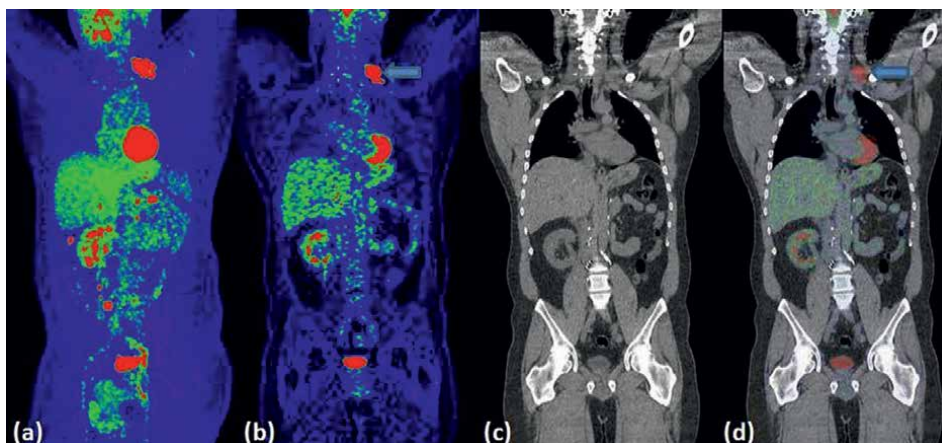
(a) FDG PET MIP image of patient with RCC (b) coronal PET image (c) coronal CT scan image and (d) PET/CT scan fusion image of similar patient. Left supra clavicular regional metastatic lymph nodes are clearly visualized in PET/CT scan (blue arrow) which was not seen on CT scan (c) [19].
